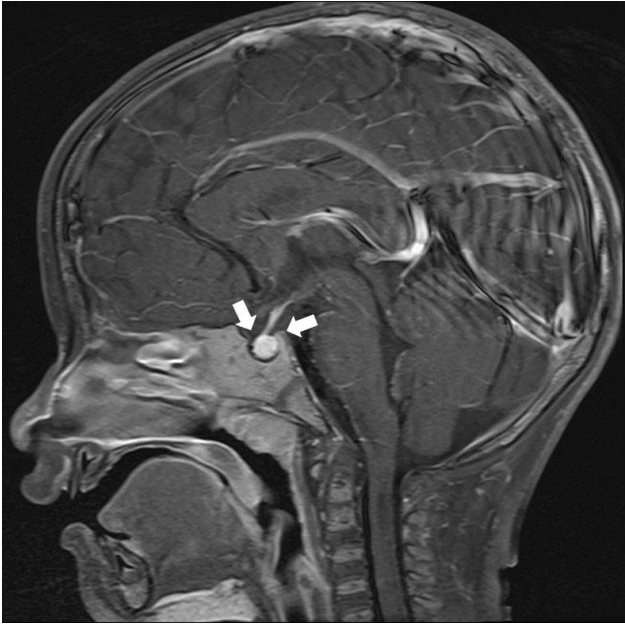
Magnetic Resonance Imaging of sella Brain and pituitary MRI showed a normal pituitary gland with a mild elongated height compatible with the change of CPP, but no other organic causes for CPP were detected.
